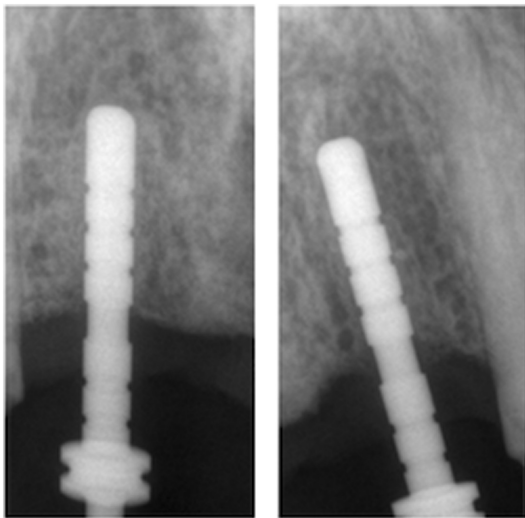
Periapical radiograph showing the direction indicator.
